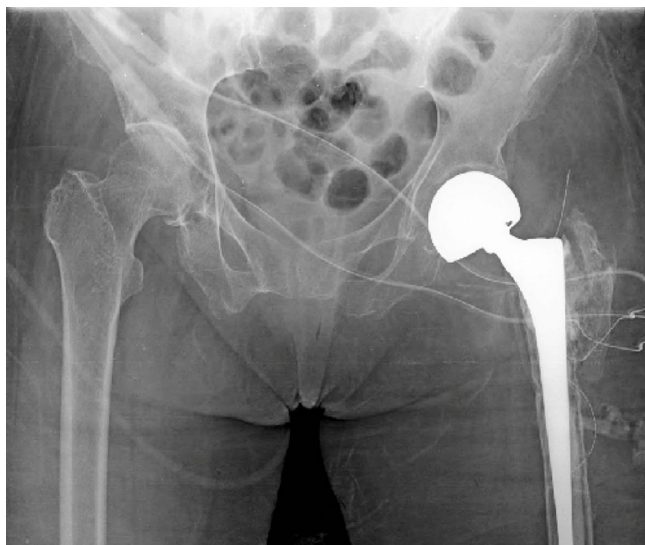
Immediate postrevision operative plain radiograph.
